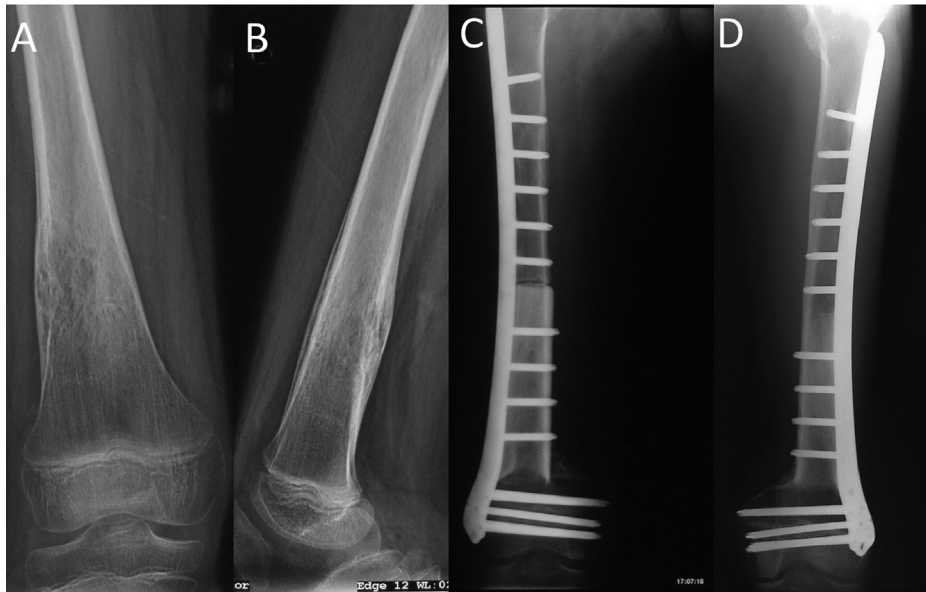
Case 15. An 11-year-old boy with stage IIB osteosarcoma at the distal third of the femur. Preoperative X-ray showed the tumor on the anteroposterior view (A) and the lateral view (B). (C) At postoperative 6 months, bone union was observed at the distal allograft-host junction, and partial weight bearing was allowed. (D) At postoperative 1 year, bone union was observed at both allograft-host junctions, and full weight bearing was allowed.
